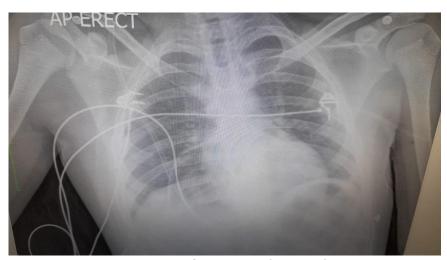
Chest X-ray (post-op)
